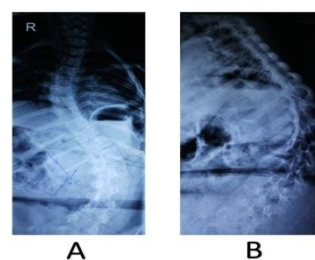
Pre-operative x-rays; (A) anteroposterior (AP) view, (B) lateral view
